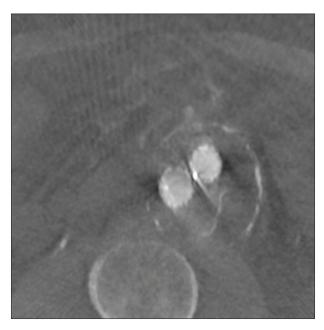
CBCT showing a large type II endoleak not detected on standard DSA.
